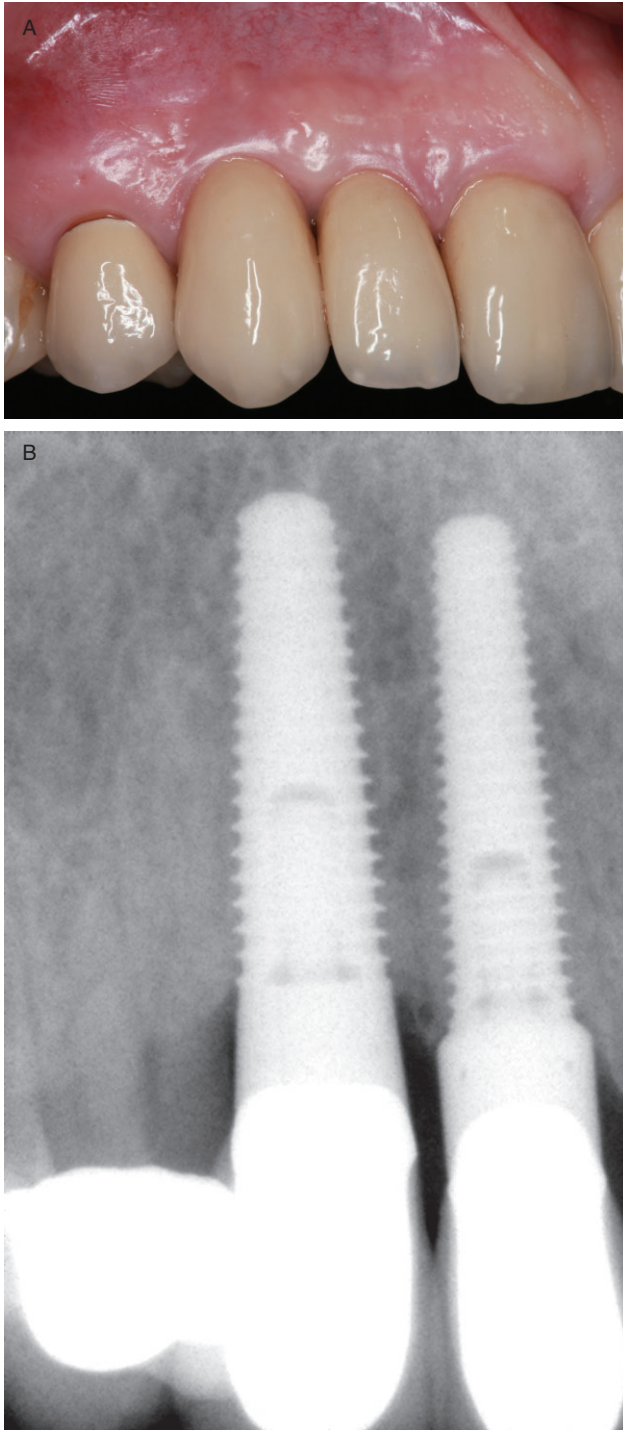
Replacement of adjacent teeth in the right maxilla. (A) Clinical aspect 78 months after immediate implant placement. Height of the mesial papilla of the lateral incisor decreased slightly. The interproximal papilla height is stable although the interimplant distance is just 1.5 mm. The PES ratings are 13 (right cuspid) and 12 (right lateral incisor). (B) Intraoral radiograph 78 months after surgery. The marginal bone levels have stabilized slightly coronal to the first thread. (PES = pink esthetic score.)
